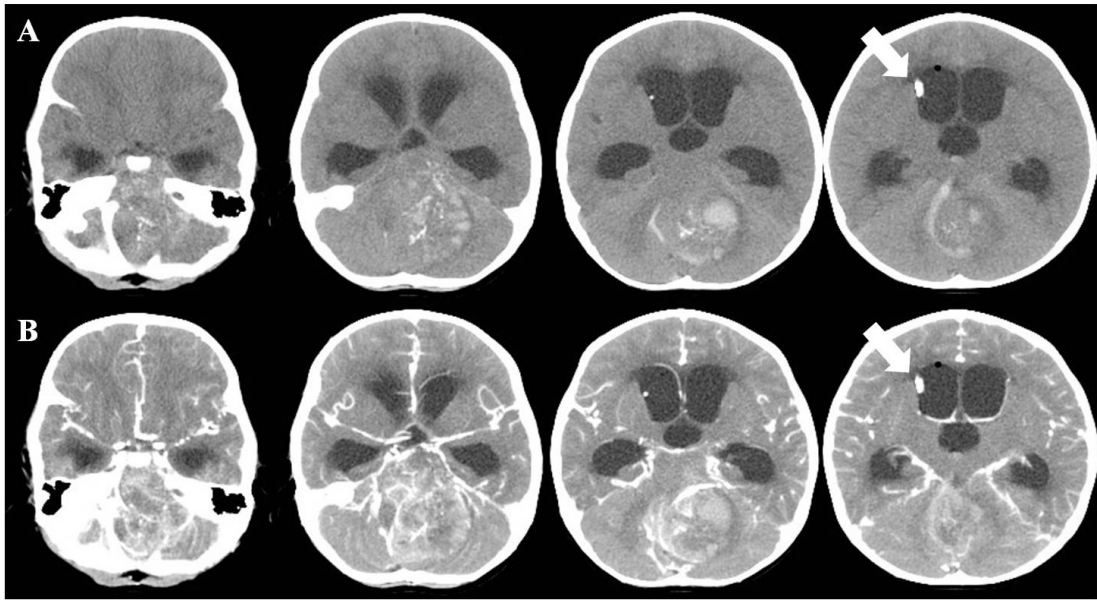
Axial brain computed tomography images obtained in the emergency department: pre-contrast scans (A) and contrast-enhanced scans (B). A mass lesion was suspected, with internal calcification and hemorrhage, in the mid portion of the cerebellum in A and strong enhancement of the lesion is observed in B. Note the enlarged ventricles, due to compression by the mass lesion, and the inserted external ventricular drainage catheter (white arrows).
